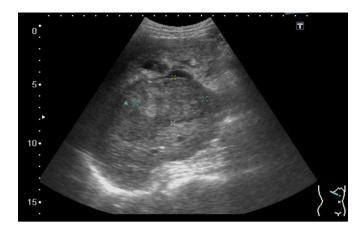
Abdominal sonography showing a  $5.9 \times 3.9$  cm heterogeneous mass in segments 5-7 of the liver.
